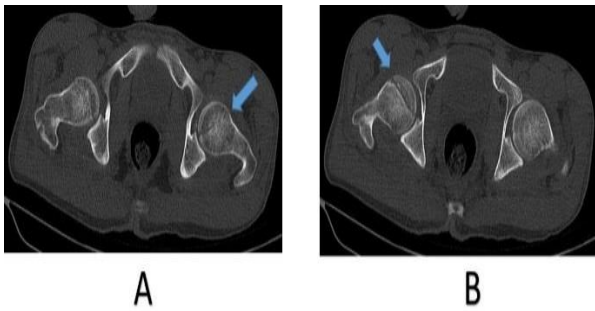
Post-reduction computed tomography (CT) scan: Fracture of the femoral head on both sides in axial view of the pelvis (arrows)
